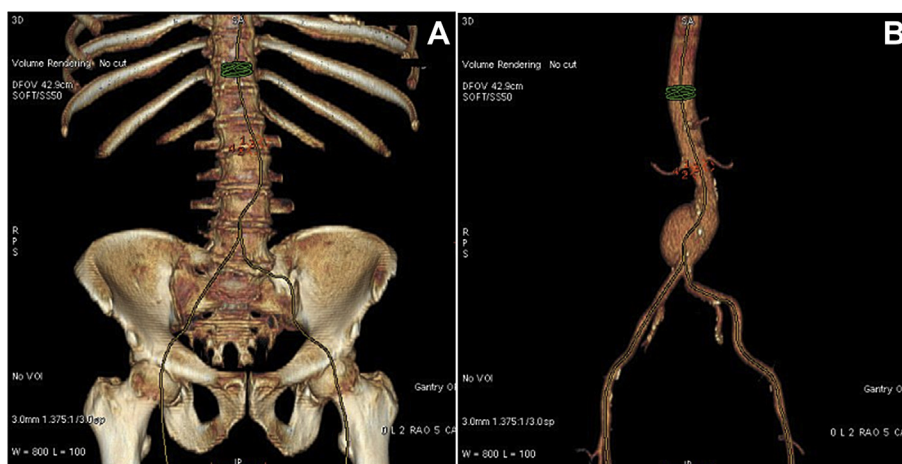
(A) A bone and (B) an aortic three-dimensional volume rendering model were reconstructed from the preoperative computed tomography angiography on a workstation (Advantage Workstation; GE Healthcare, Chalfont St Giles, UK).
